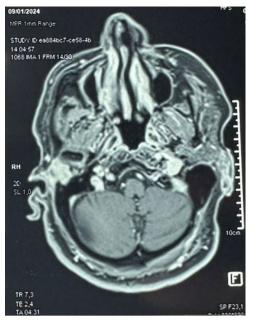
T1 MRI axial cuts reveals irregular, circumferential thickening of the partially stenosed right external auditory canal, with evidence of a nodular lesion adjacent to its posterior wall, measuring 12 mm × 6 mm and an accidentally discovered cholesterol granuloma of the contralateral petrous apex.
